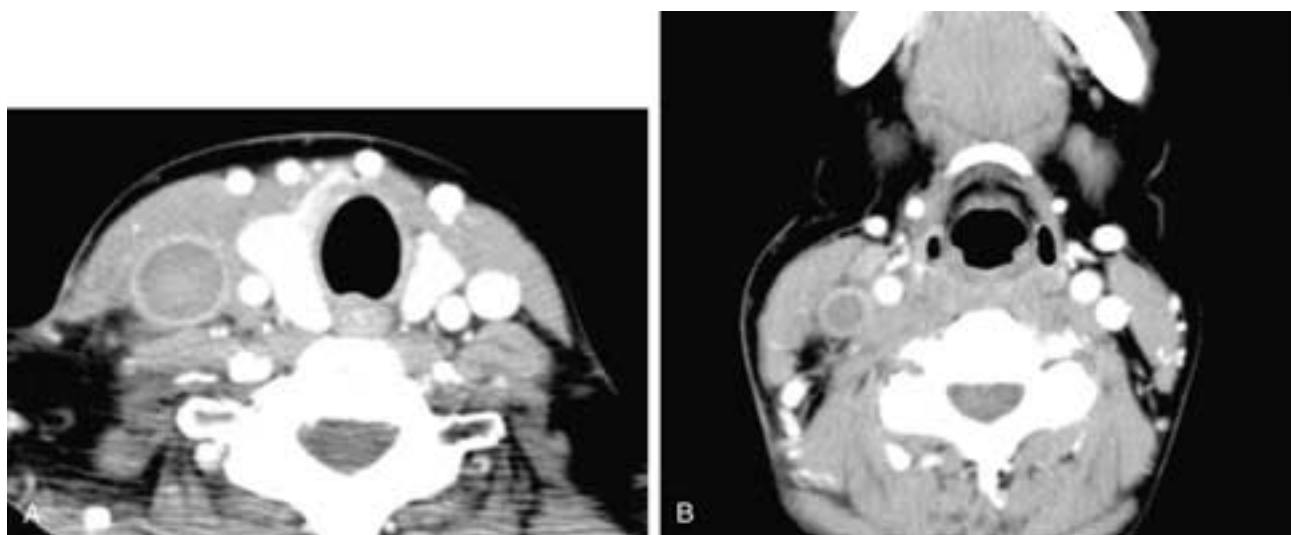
Axial contrast-enhanced CT scan (A) shows a "cyst" in the right neck. The internal jugular vein is not identified. More cranially in the neck (B), the thrombosed internal jugular vein is again seen. The tubular configuration and its replacement of the internal jugular vein establishes the diagnosis.
